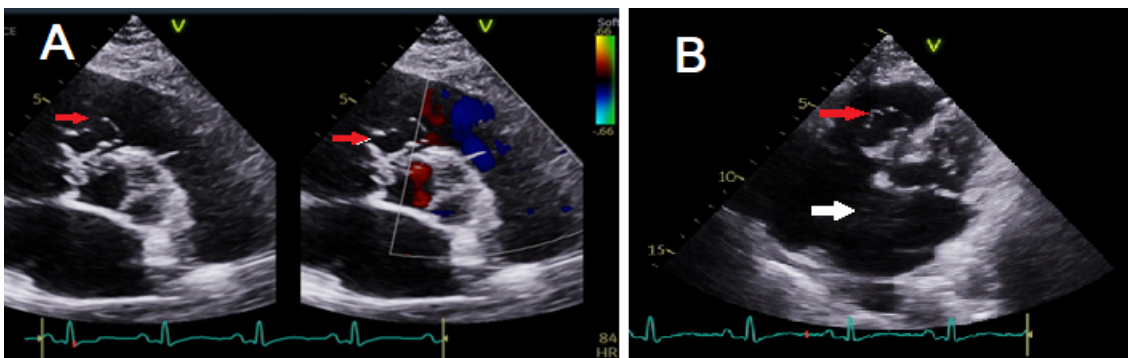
Transthoracic echocardiography. (A) Color flow imaging in parasternal short-axis view showing a ventricular septal aneurysm (red arrow). (B) Modified apical view showing aneurysm (red arrow) and atrial septal defect (white arrow).
